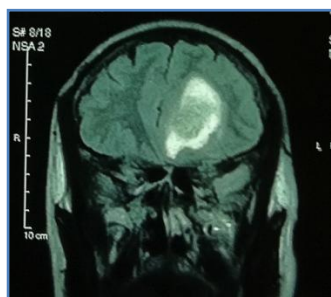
Coronal FLAIR images show heterogeneous area of altered signal intensity seen involving the ethmoid sinus and nasopharynx with intracranial extension involving frontal lobe parenchyma on left side with perilesional edema.
